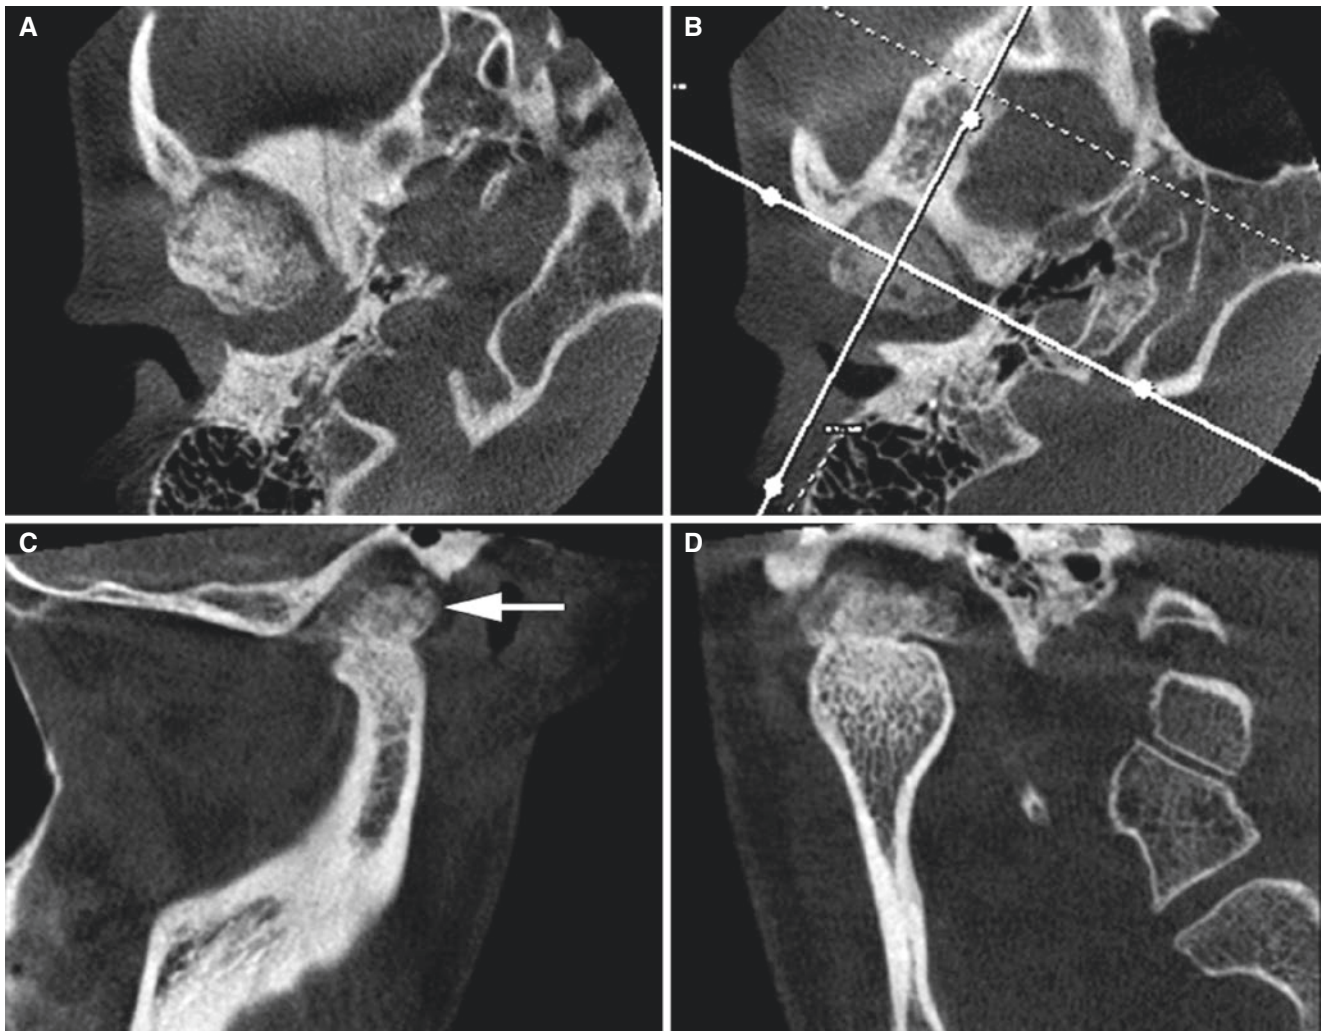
Osteochondroma (most probable); 26-year-old female with some jaw asymmetry. (A) Axial, (B) axial (with cursor lines), (C) oblique sagittal, and (D) oblique coronal CBCT images show condylar hyperplasia with irregular outline (*arrow*)
